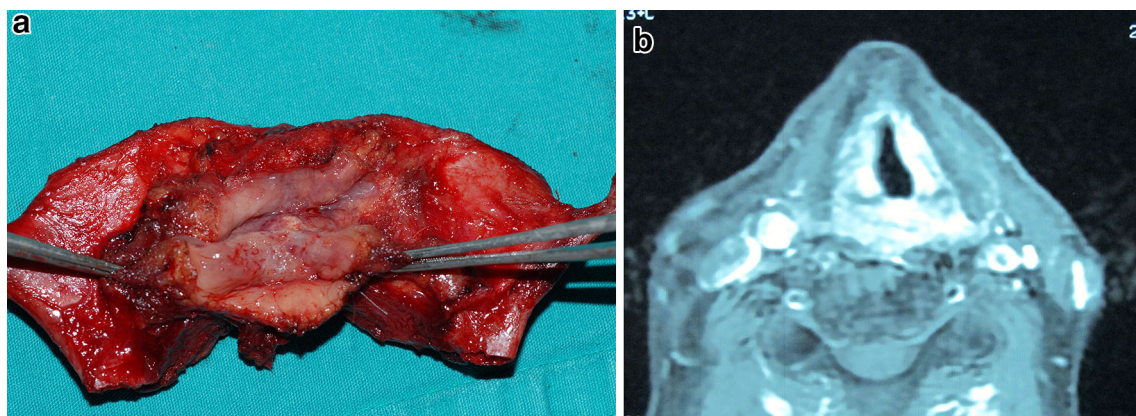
a Tumor limited to the glottis with AC involvement. b T1-weighted contrasted MRI image of the same patient showing any invasion of the thyroid cartilage
